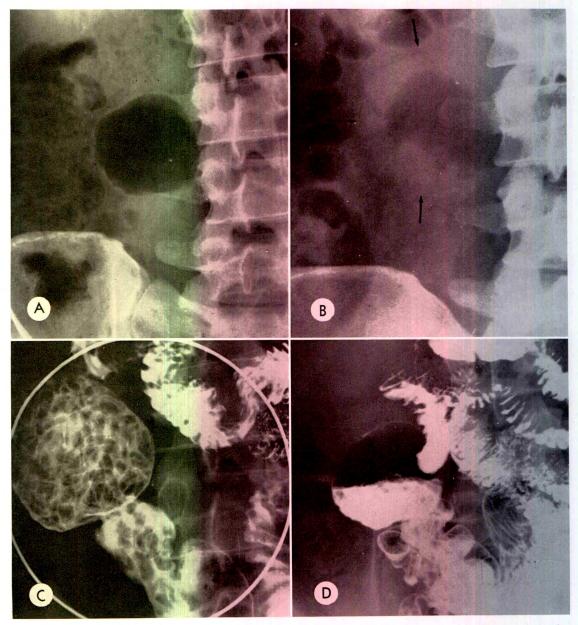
Case I. (A) The discrete, rounded, gas-containing structure visualized to the right of the lumbar spine at the level of L 3 represents the blind pouch in the proximal segment of the distal ileal anastomosis (plain roentgenogram, recumbent). (B) The pouch is visible in the same areas as a globular soft tissue density when it is filled with fluid (arrows). There is a radiolucent central area indicating gas on the surface of the fluid (recumbent). (C) Detail study of barium filled blind pouch in the distended state (gastrointestinal series). The pouch is spherical and has a narrow neck. This is a distinctive appearance (see Fig. 3B and Fig. 8). The filling defects were produced by small fecal masses of the consistency of putty, measuring approximately I cm. in diameter. No barium has as yet passed through the stoma to enter the distal segment of the anastomosis. (D) Barium-filled pouch in the right lower quadrant (erect position) shows layering of air-barium mixture.
